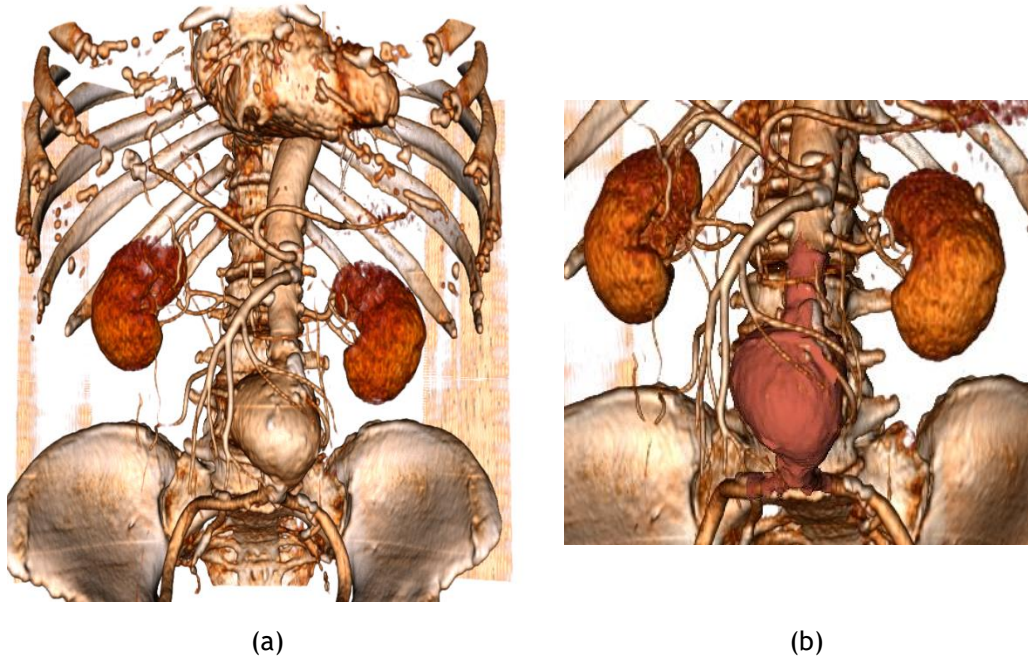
23 - Abdominal Aortic Aneurysm: (a) DICOM image obtained from CTA and (b) aneurysmal mask.
